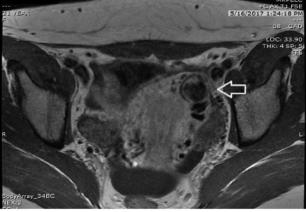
Multiplanar MR images reveal vascular malformation in uterine fundal myometrium on left side (arrow) with serosal bulge and no extension into the endometrial canal.
